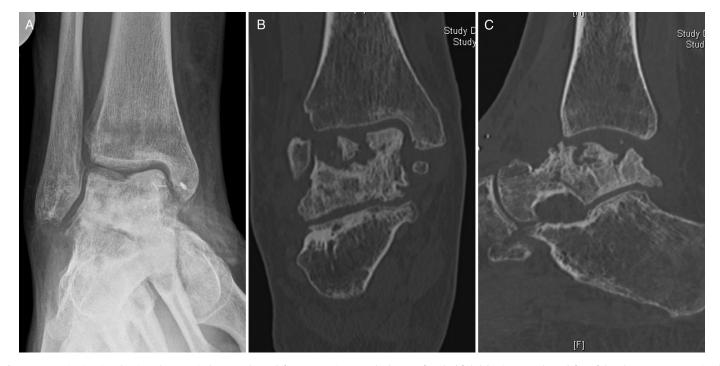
Preoperative imaging showing talar necrosis due to a talar neck fracture. Previous vascular bone grafting had failed, leaving a vast bony defect of the talus seen on conventional radiographs (A) and computed tomography scans (B and C).
